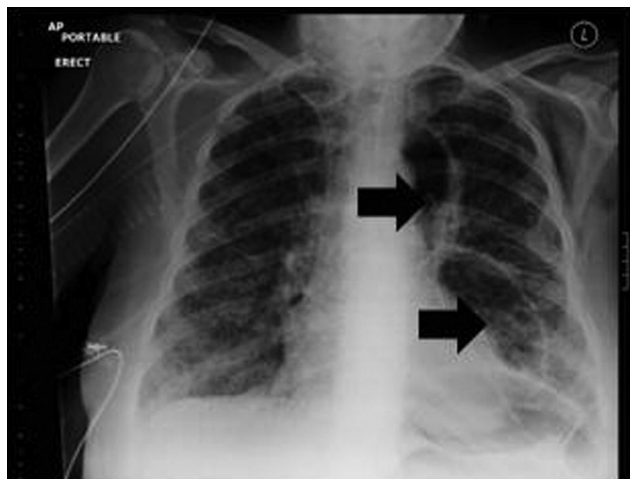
Chest radiograph shows a left-sided loculated pneumomediastinum. There is a chest drain in situ.
